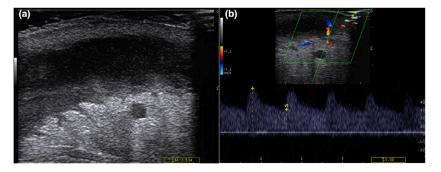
Ultrasound aspect of a fluid collection (a) and colour Doppler evaluation (b).
